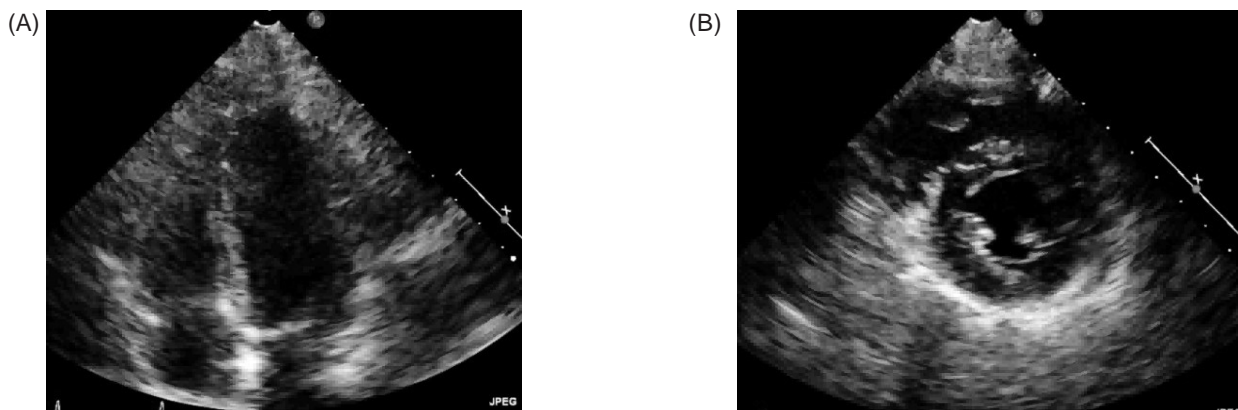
(A) Four-chamber view of the patient's echocardiogram. (B) Short-axis view of the patient's echocardiogram. The images of (A) and (B) show the normal RV size. RV = right ventricle.
